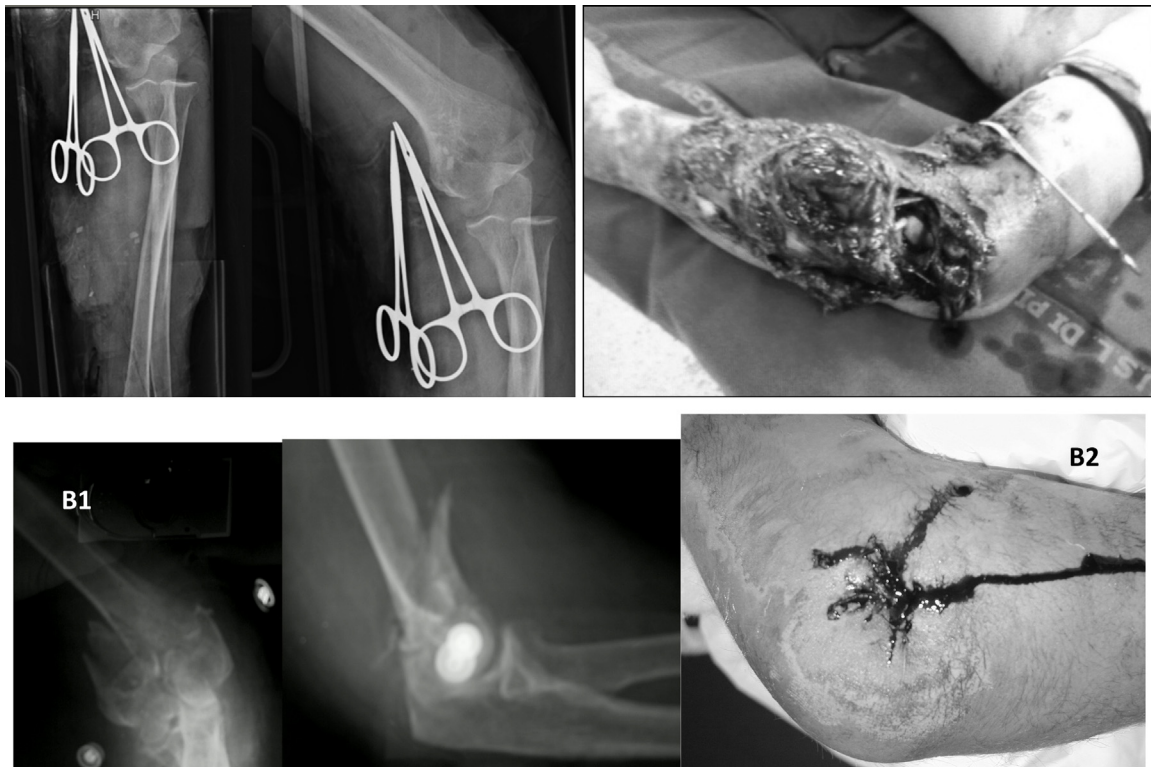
Case 14: AP and lateral radiographs (A1), and the clinical picture (A2) of a patient with coronoid fracture and open grade 3C elbow dislocation (neurovascular lesion). Case 1: AP and lateral radiographs (B1), and the clinical picture (B2) of a patient with a distal humeral AO 1.3 C2 grade 2 open fracture.
